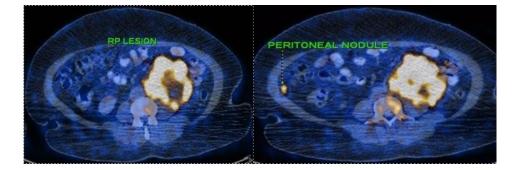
PET CT showing the left para vertebral mass and the peritoneal nodule
